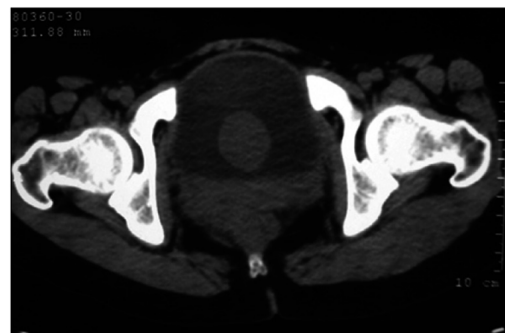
Contrast computed tomography scan of the pelvis showing the bladder mass near the bladder neck [18]
